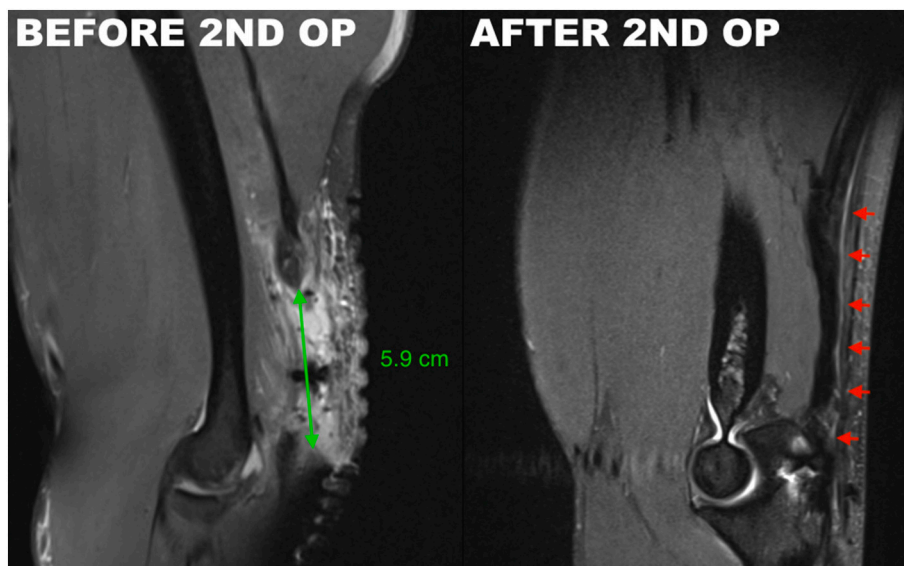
MRI comparison before and after the 2nd operation.
